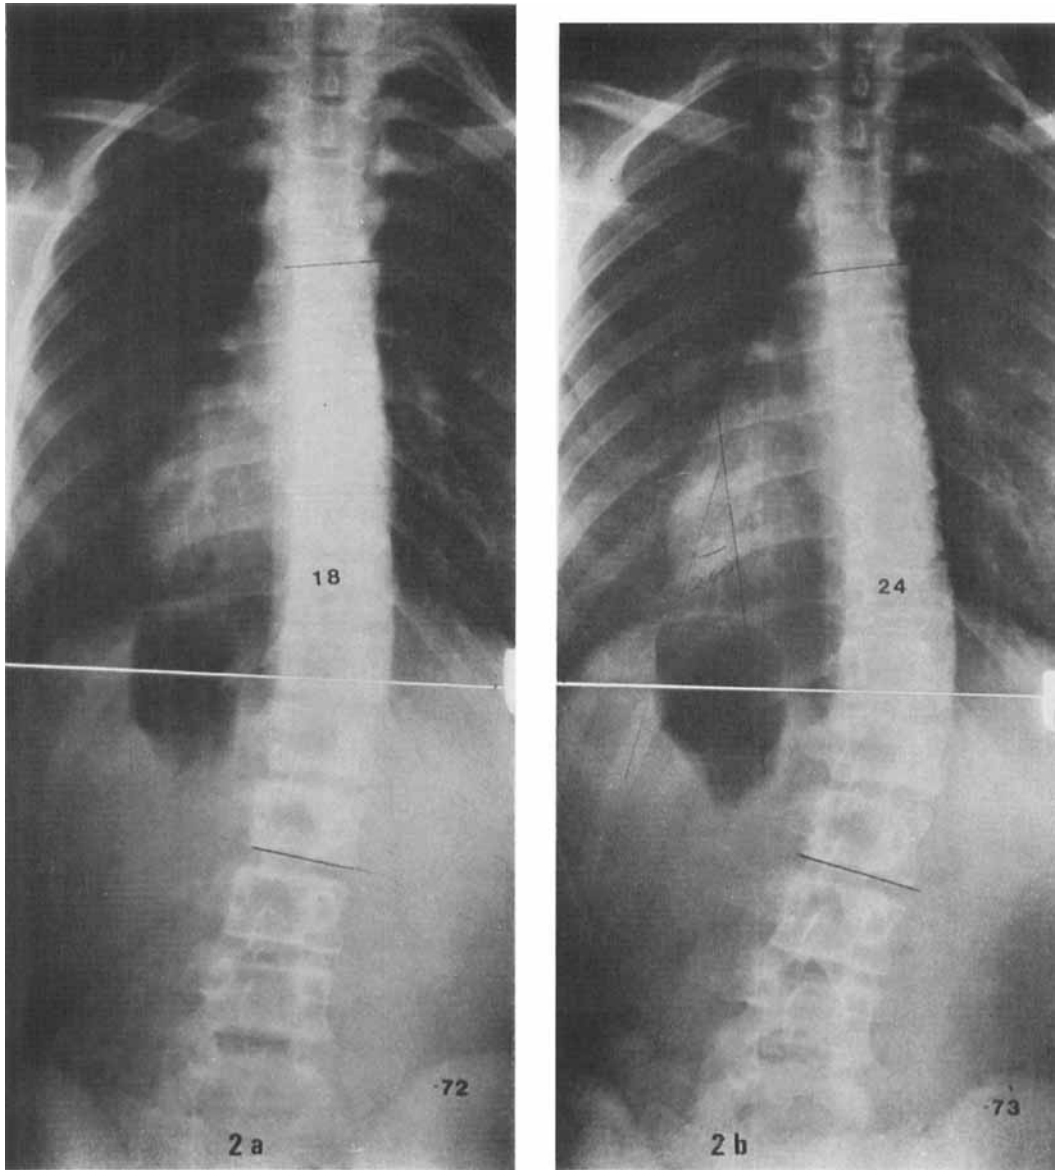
X-rays of the same girl as in Figure 1; at 12 years (a), at 13 years (b), and at 16 years (c) of age. She has now developed a right-sided progressive type of idiopathic scoliosis.
